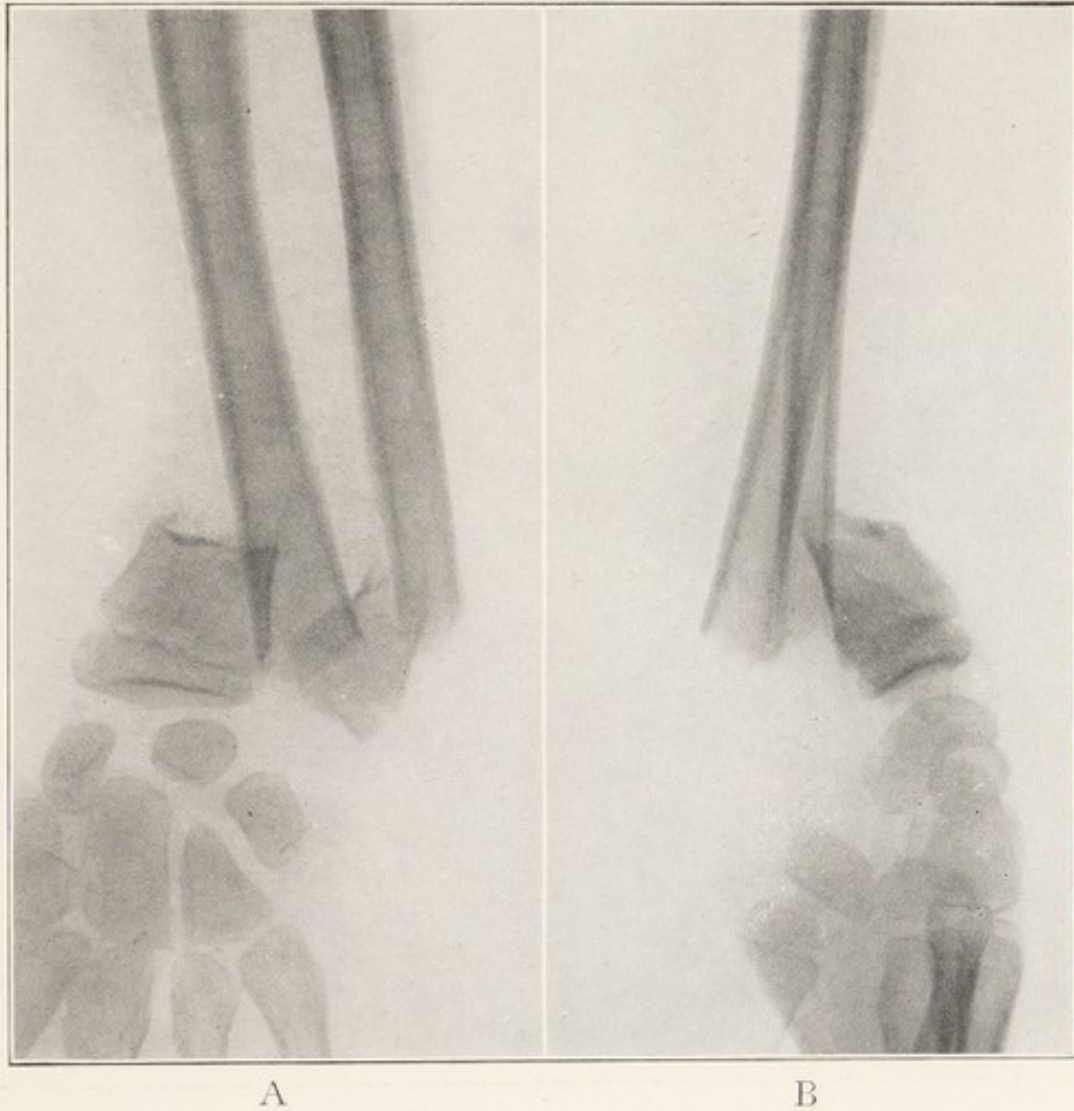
X-RAY OF FRACTURE OF BONES OF FOREARM, ANTEROPOSTERIOR VIEW.
